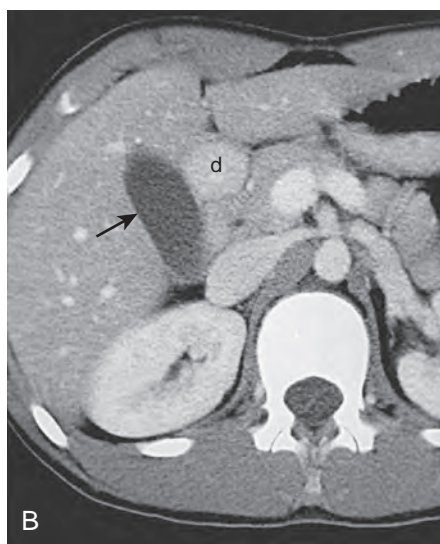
Normal gallbladder anatomy: CT. A. The gallbladder appears as a fluid-filled ovoid structure (arrows) in the interlobar fossa of the liver. B-D. Sequential CT scans show the normal position of the gallbladder (arrows) between the right and left lobes of the liver and the relationship of the gallbladder to the antrum (asterisk in C and D), duodenal bulb (d in B and C), and C-sweep of the duodenum (d').
